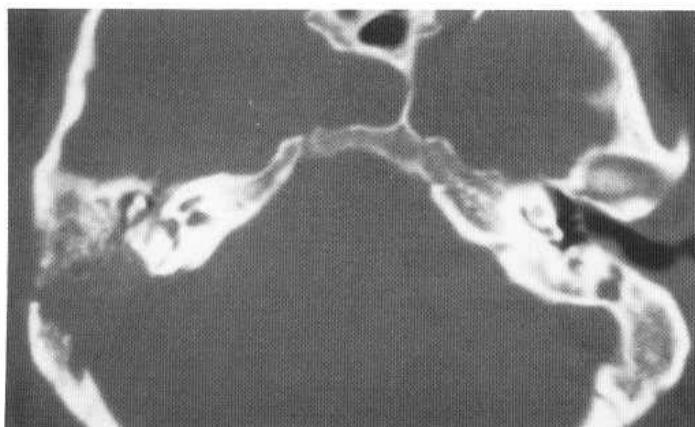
Ragged erosion of the right mastoid region by a carcinoma shown on this axial CT section.
